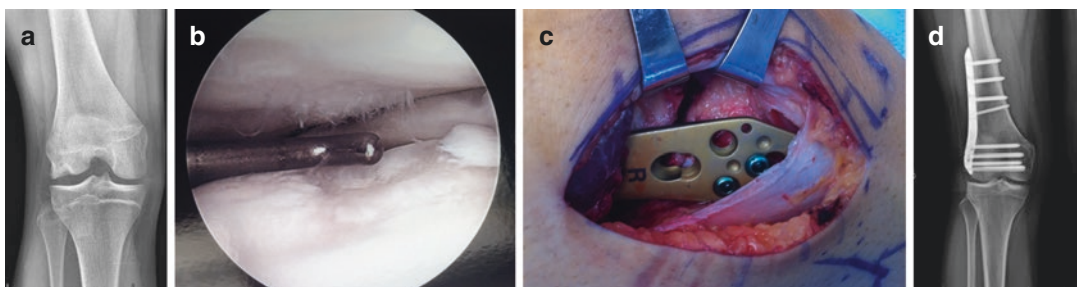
Lateral opening distal femoral osteotomy (DFO). (a) Preoperative radiographs of a 19 yo runner with symptomatic lateral compartment OA. (b)
